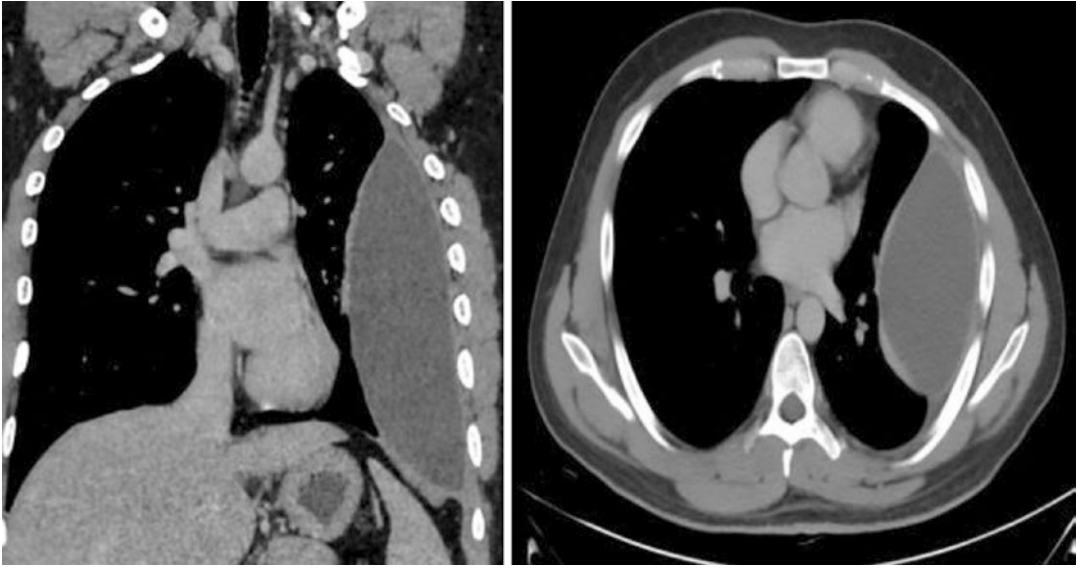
CT image showing left-sided tubercular empyema compressing the left lung, necessitating decortication surgery
